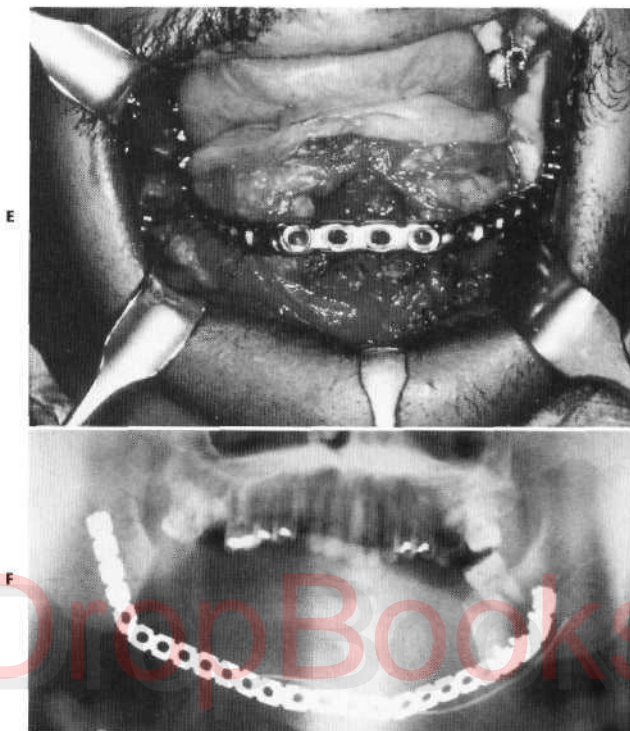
cont'd E, Placement of large metal bone plate to reconstruct mandible after tumor rejection. The plate is attached to both rami and provides support to the overlying soft tissues to prevent their contraction during the healing process. The tongue musculature is sutured to the bone plate to maintain its forward position, ensuring patency of the airway. F, Panoramic frontal radiograph showing bone plate in position.
